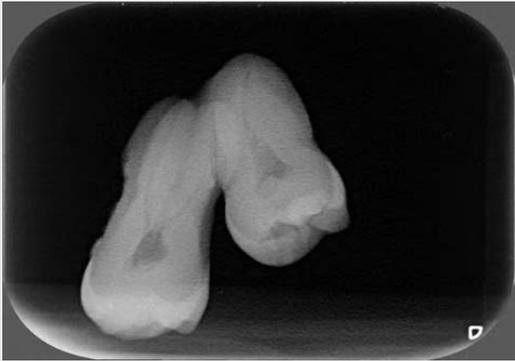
Digital periapical radiography showing concrescence.
